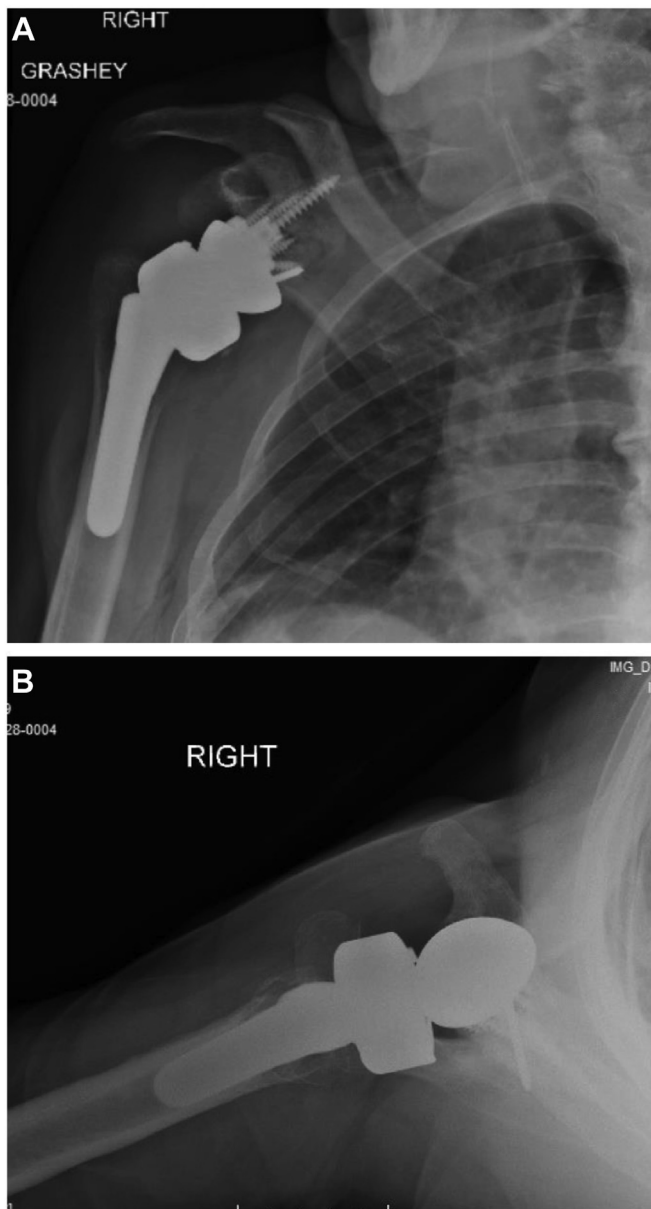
Postoperative Grashey (A) and axillary (B) radiographs of the same patient in Figs. 1 and 2. Revision rTSA implantation included distal clavicle autograft fixed with a 3.0 mm screw, +10 humeral tray, +3 retentive E1 polyethylene liner, 25 mm glenosphere baseplate with 6.5 × 40 mm central non-locking screw and 4 peripheral locking screws (15, 20, 20, 30 mm), and a 41 mm standard offset glenosphere with Versa-Dial adapter set to E. The humeral stem in the primary surgery was not removed and only the humeral tray and liner were replaced. Glenoid and humeral components remained well fixed at follow-up. rTSA, reverse total shoulder arthroplasty.
